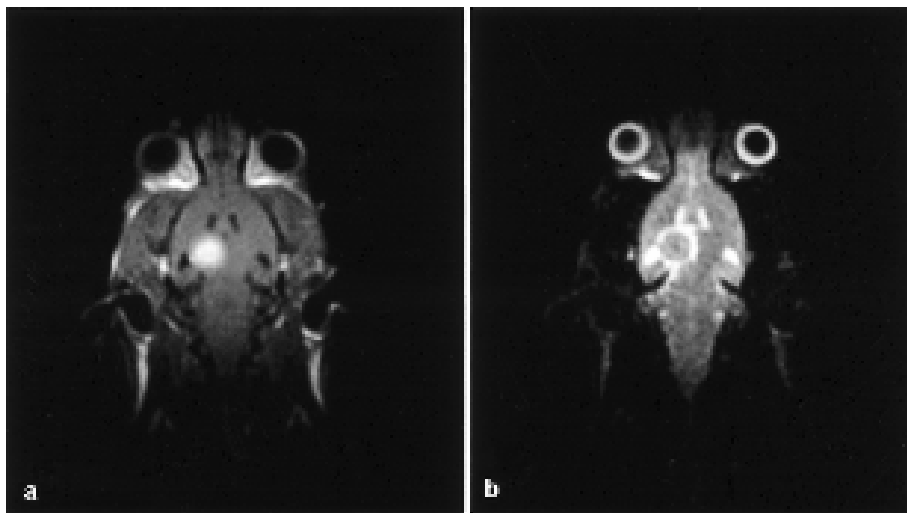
Axial MR images of untreated tumor; a T<sub>1</sub>-weighted post-contrast, b T<sub>2</sub>-weighted pre-contrast. The peritumoral edema is clearly delineated.
